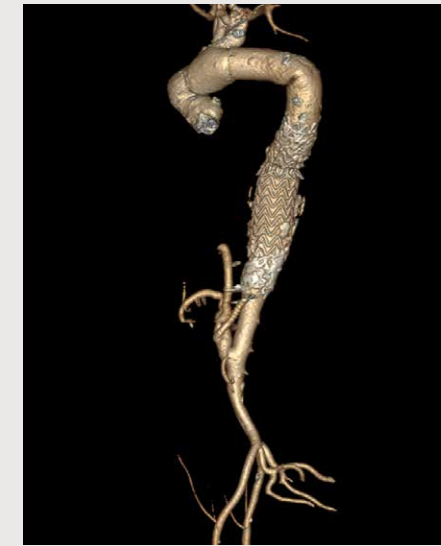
CT 3D reconstruction of demonstrated patient's previous aortic elephant trunk procedure, thoracic aortic stent, and visceral debranching.
